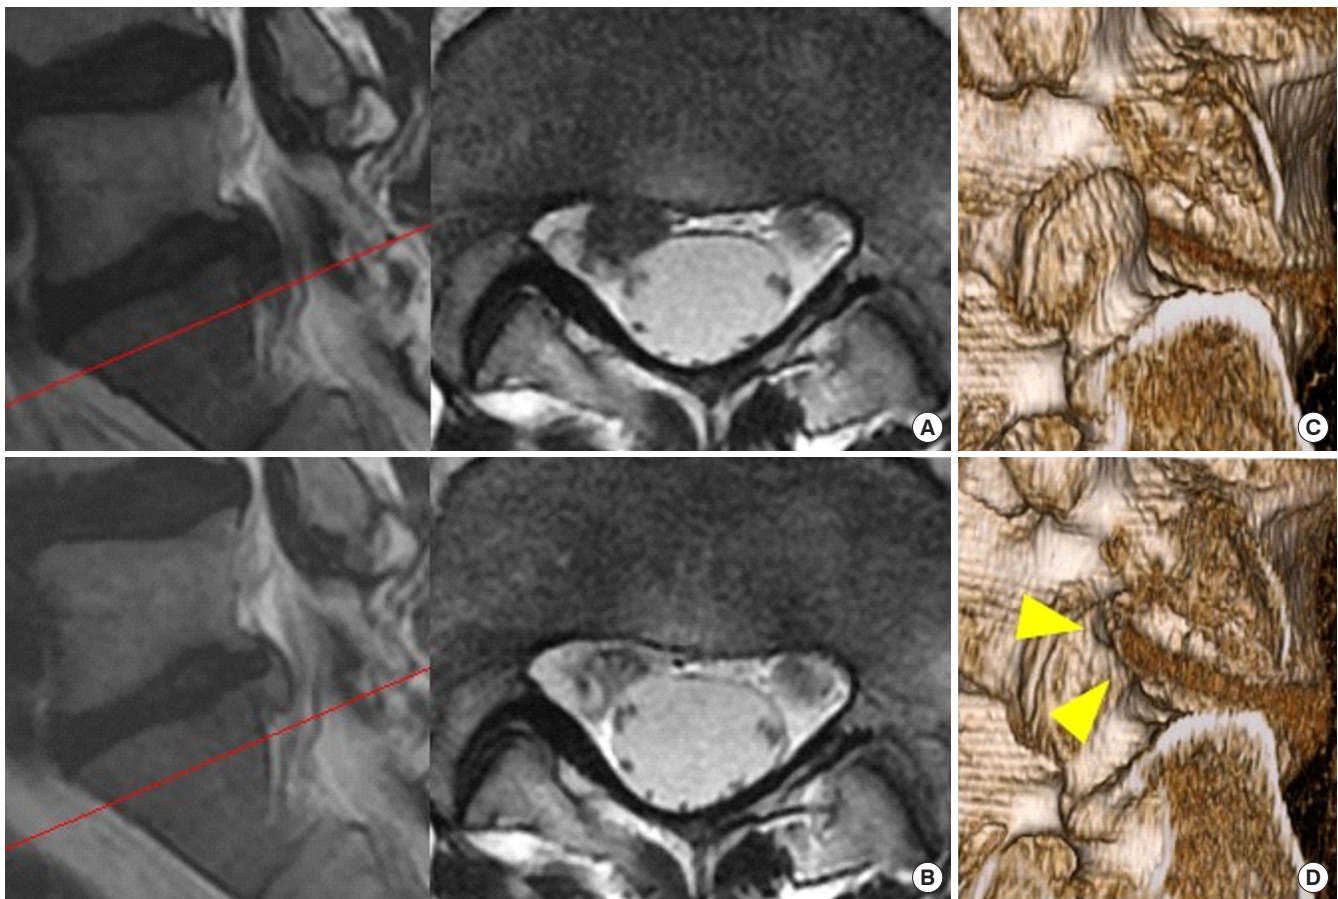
Representative case with superior articular process (SAP) removal. Preoperative (A) and postoperative (B) magnetic resonance (MR) images of case 16. Sagittal (left) and axial (right) T2-weighted MR images are shown (the red line on the left sagittal image indicates the level of the right axial image). Preoperative (C) and postoperative (D) 3-dimensional computed tomography (3D CT) findings of case 16. (C) Preoperative 3D CT revealed SAP hypertrophy. (D) After removal of the SAP tip, the entry point on the L5/S1 disc surface is exposed (arrowheads).
